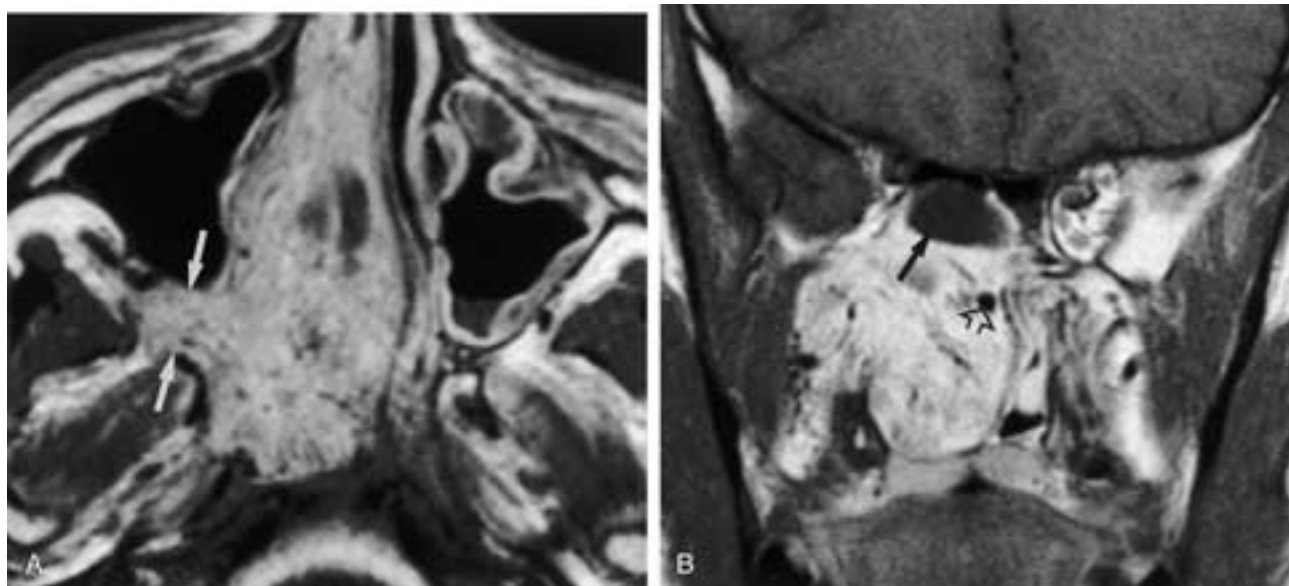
JNA in a 14-year-old boy with chronic nasal obstruction and epistaxis. A, Axial contrast-enhanced T1-weighted MR image shows an intensely enhancing tumor filling the right nasal cavity and deviating the nasal septum. The pterygopalatine fossa and pterygomaxillary fissure are widened and filled with tumor (*arrows*). There is anterior displacement of the posterior wall of the right maxillary antrum. B, The coronal contrast-enhanced T1-weighted image reveals flow voids within the tumor (*open arrow*). The cephalad extent of the tumor is well seen on the coronal images. There are retained secretions within the sphenoid sinus (*arrow*).
